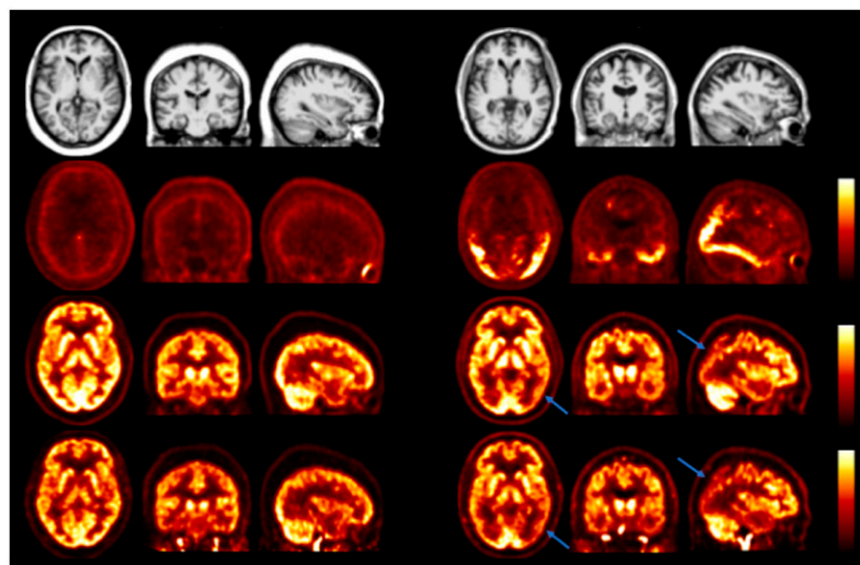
Quantitative measurement of cerebral perfusion from early-phase ^{18}F -MK6240 tau PET imaging. Parametric maps of images in a control subject (left 3 columns) and a subject with Alzheimer disease (AD; right 3 columns) showing (top to bottom): multiecho MPRAGE MR, ^{18}F -MK6240 PET late SUV ratio (90–120 min, 0–3.5), ^{18}F -MK6240 early-phase relative perfusion (R1, 0–1.3); and ^{11}C -PiB early-phase relative perfusion (R1, 0–1.3). Blue arrows indicate areas of reduced cerebral perfusion and corresponding high tau load. Strong correspondence was seen between the already established relative delivery of the ^{11}C -PiB amyloid tracer and the newer MK tau compound. Early and late phases of ^{18}F -MK6240 dynamic acquisition may offer complementary information about the pathophysiologic mechanisms of AD.
